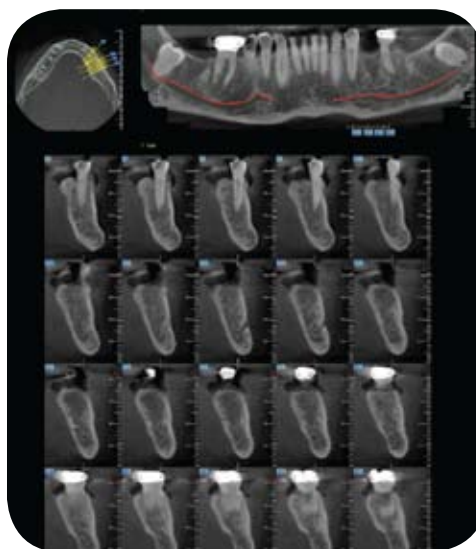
Axial, panoramic, and cross-sectional views of a CBCT scan. (Images created in NewTom software, C-Dental X-Ray, Inc.)
